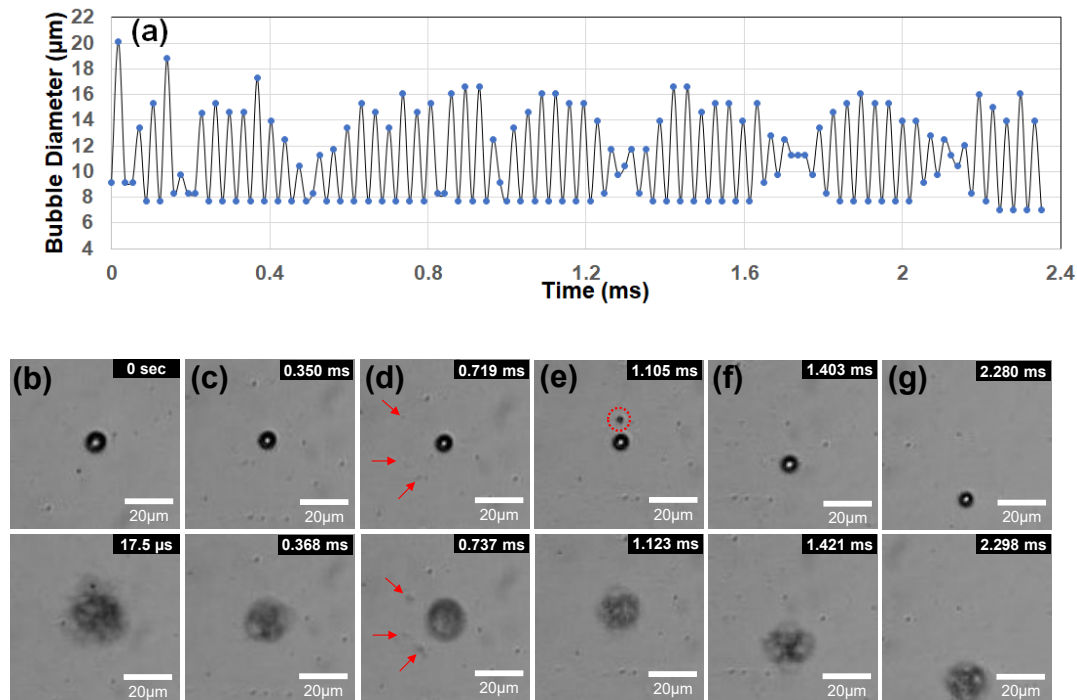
(a) A single lipid-DDFC droplet with an initial diameter of $9.17\ \mu\text{m}$ exhibited 62 consecutive vaporization-condensation cycles using $1.7\ \text{MHz}$ ultrasound and sampling time of $17.54\ \mu\text{s}$. (b)-(g) Six vaporization-condensation images of the droplet sample. After the first vaporization, the bubble size decreases slightly with increasing cycles. Bubble fragmentation was observed to occur due to the expanding and shrinking oscillations in (d) and (e).
